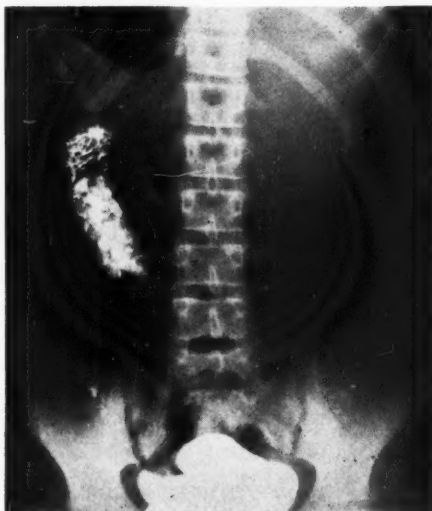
Roentgenograph taken 15 minutes after the injection of pitressin shows nearly complete evacuation with retraction of both flexures of the colon visualizing the gall-bladder and kidney areas.
